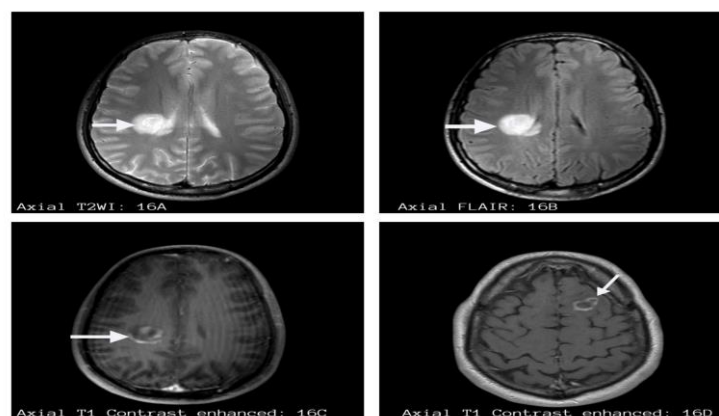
Patient with tumefactive multiple sclerosis showing T2WI (16A) and FLAIR (16B) hyperintense signal lesions in periventricular location. On T1 contrast enhanced images (16C) and (16D) only internal aspect of lesions is enhancing indicating incomplete ring enhancement.
